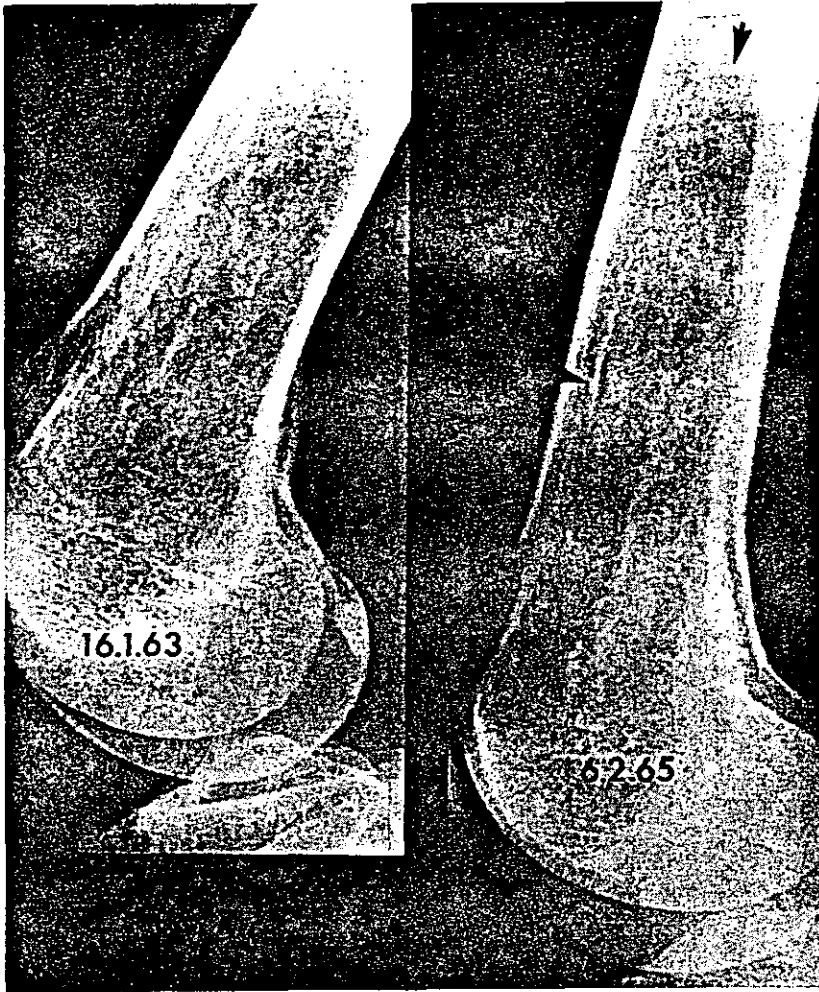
Calcification developing in the distal shaft of the femur. On the left (16.1.63) no abnormality. On the right, (6.2.65) early calcification is present (arrows). Note the importance of good quality radiographs showing trabecular detail. If this is not present then early calcification will not be defined.
